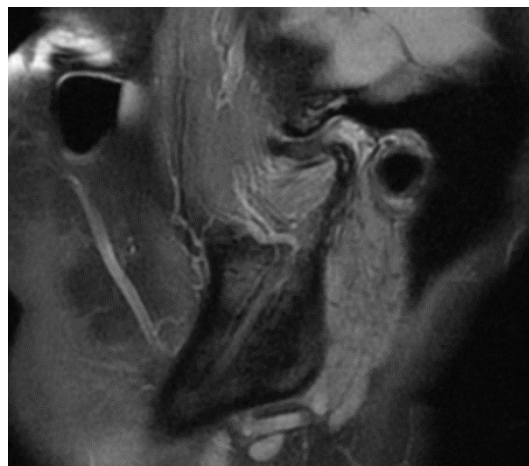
Right temporomandibular joint sagittal image with open mouth PD MRI: the altered articular disc remains anteriorly displaced relative to the condyle: disc displacement without reduction.
